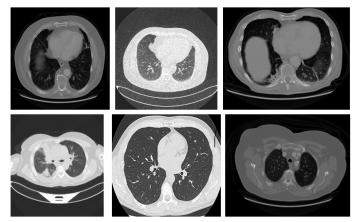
Sample CT scan images from the test set across all six lung cancer classes used in this study.
